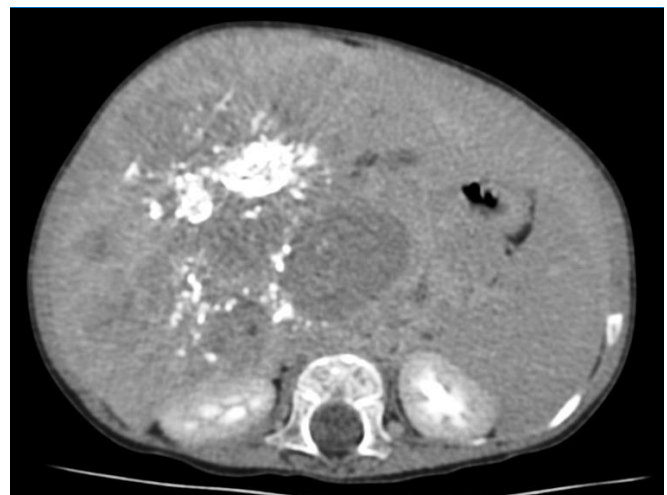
Axial CT Abdomen image in delayed phases shows washout of contrast
